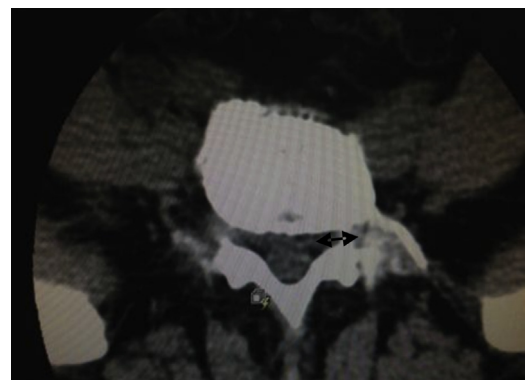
CT scan. Arrow indicate right lateral recess stenosis.
